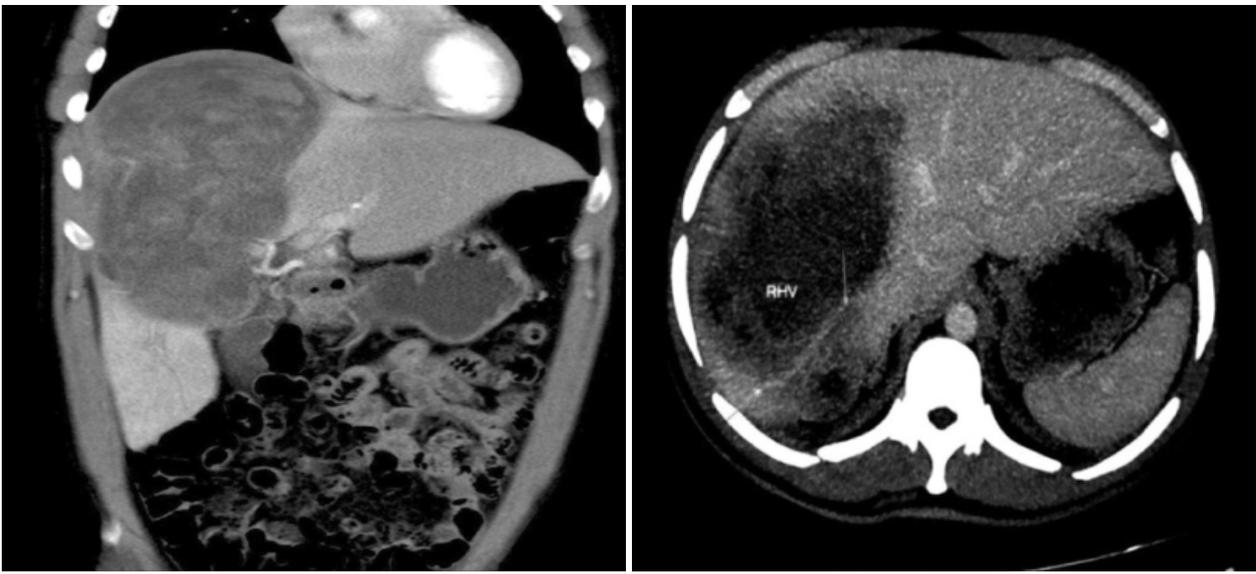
CT scan of the abdominal cavity
